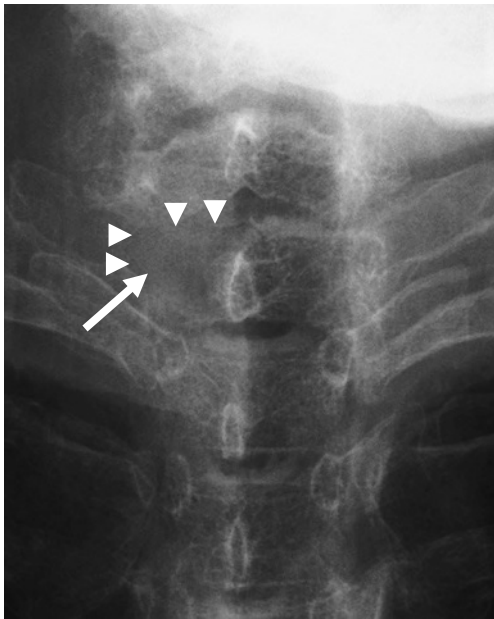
Radiograph showing a complete pedicle sign in a 73-year-old woman with a multiple myeloma lesion in the first thoracic vertebra. The shadow of the right pedicle on an anteroposterior radiograph has disappeared completely (arrow). The vertebral cortices at the upper right and lateral sides have also disappeared (arrowheads).
